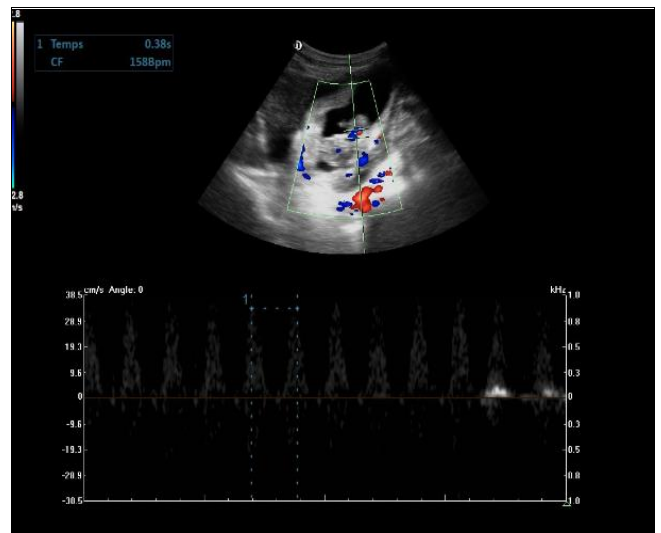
Ultrasound section showing positive fetal cardiac activity
